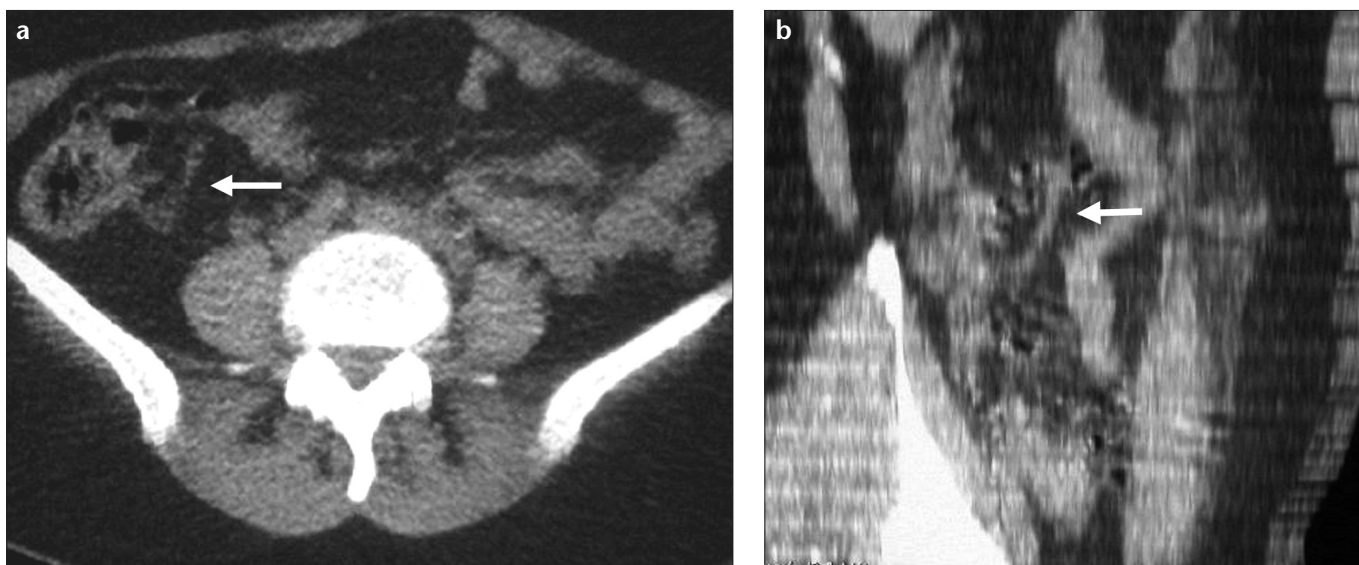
Axial CT section (a) and coronal-oblique MIP image (b) show an appendix located medial to the caecum (*arrow*). Note also that the origin of the appendix and ileocaecal valve are at the same level.
